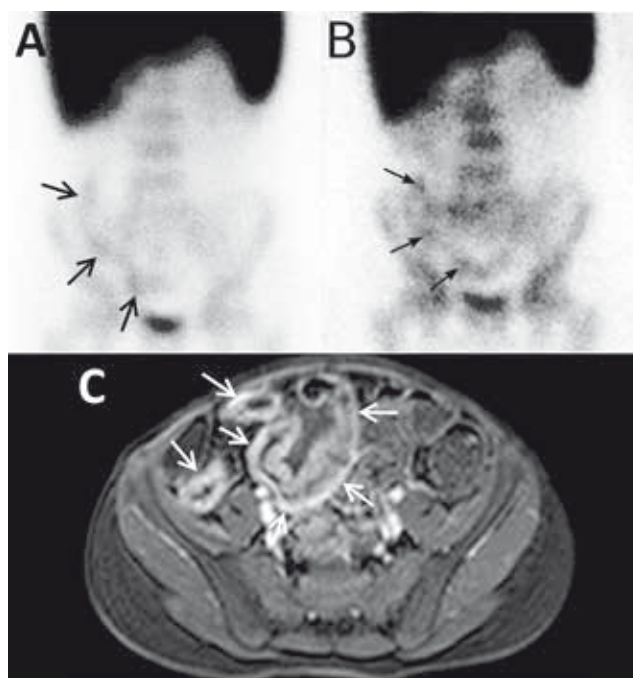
Crohn's disease with ileocecal involvement. An early scintigram in an 11-year-old boy with a pathologic accumulation of labeled leukocytes in the right lower abdominal quadrant corresponding with the location of the terminal ileum, caecum, and the ascending colon (Cheow score 3C) confirms the presence of Crohn's disease (A). A late scintigram with even more conspicuous pathologic accumulation (Cheow score 3C) in the same location (B). MR enterography shows marked thickening and mural enhancement of the ileum on a T1 (THRIVE) transversal section (C)
